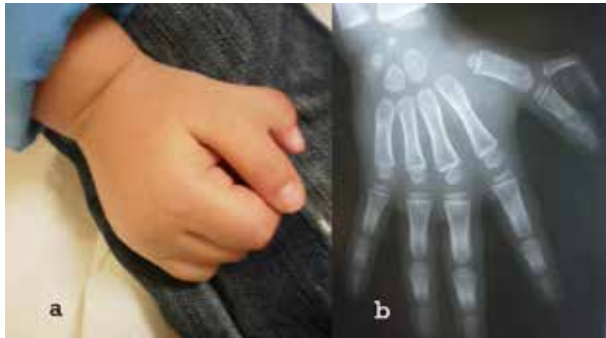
Complete thumb duplication of proximal phalanx (τύπος IV) a. clinical im-age b. radiography.
